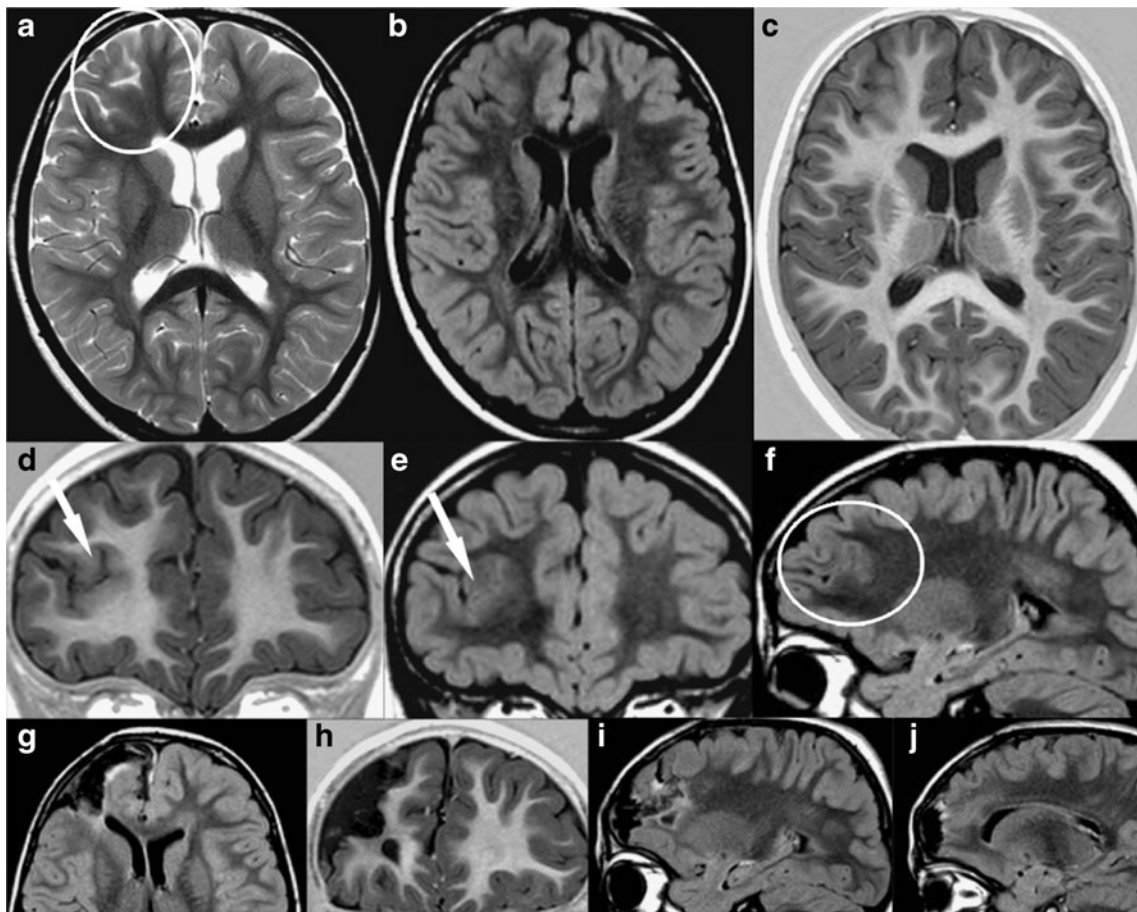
FCD IIa: a, b, c axial TSE-T2WI, FLAIR-T2WI and IR-T1WI, d, e coronal IR-T1WI and FLAIR-T2WI, f sagittal FLAIR-T2WI. Post-surgical MRI: g axial FLAIR-T2WI, h coronal IR-T1WI, i, j sagittal FLAIR-T2WI. The dysplasia involving the right frontal cortex is revealed by the presence of gyration anomaly characterized by deeply
